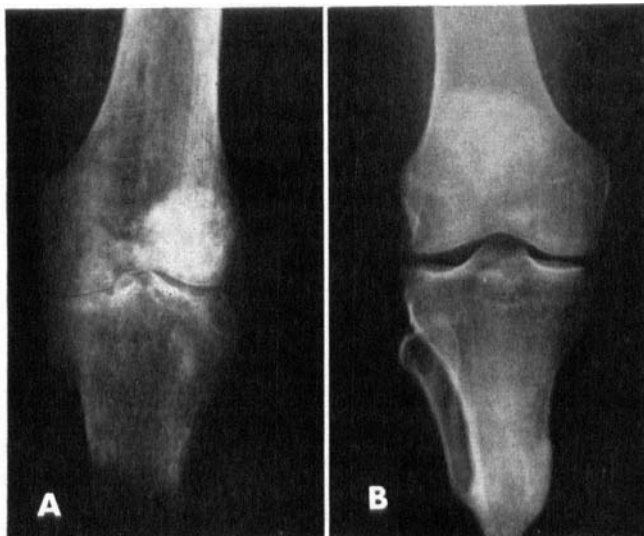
The roentgenologic appearance of the stump in two below-knee amputated patients. An extreme osteoporosis is present in the left stump one year after amputation; the right stump is sclerotic 9 years after the operation.
